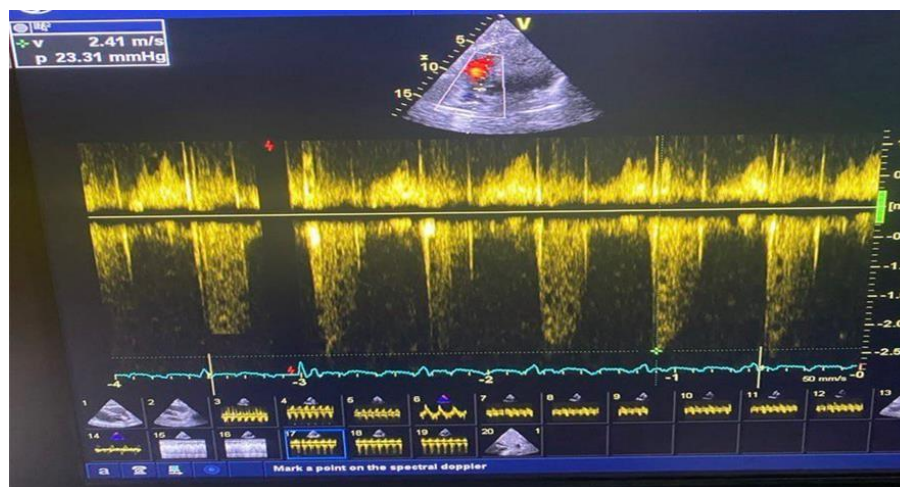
CW, Doppler measurement of tricuspid valve velocity.
